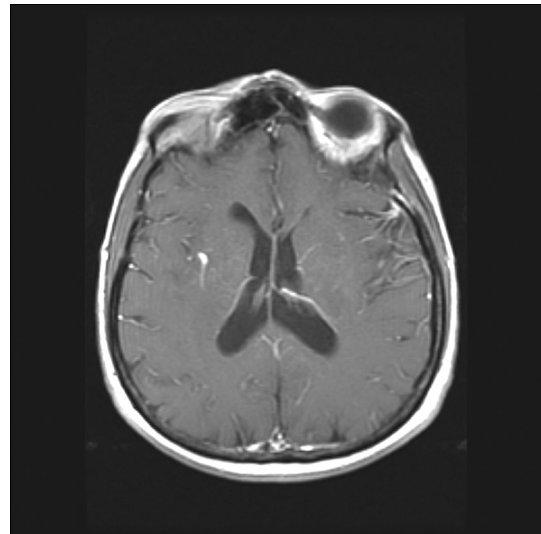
Developmental venous anomaly. Brain MRI with gadolinium shows a right basal ganglia DVA. This was an incidental finding.
